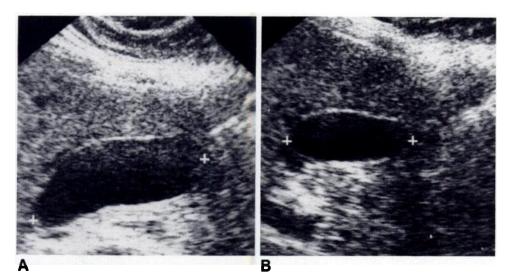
Example of gallbladder emptying in response to a fatty meal in healthy control subject. Longitudinal sonograms of gallbladder before (A) and 60 min after (B) fatty meal. Gallbladder length indicated by electronic calipers. After the meal, the gallbladder exhibited a substantial decrease in volume.
